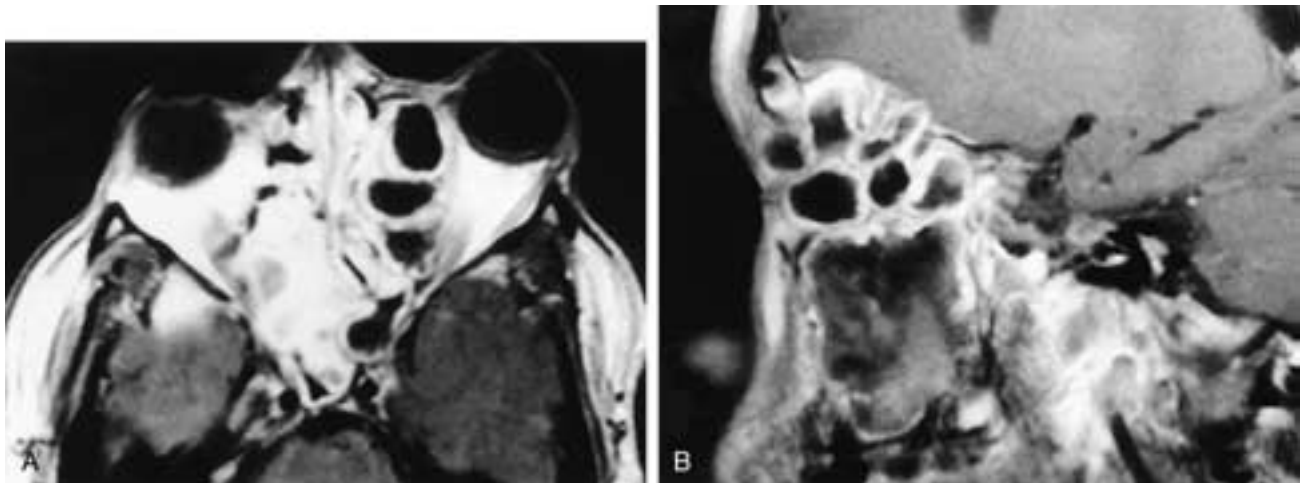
Axial (A) and sagittal (B) contrast-enhanced T1-weighted MR images show widening of the ethmoid complex by a mass that has also broken into the floor of the anterior cranial fossa and the left orbit. Enhancing mucosa is seen surrounding areas of signal void. The maxillary sinuses are also involved by the process. None of the sinuses were aerated on CT, and the areas of signal void were aspergillomas. This patient had aspergillosis.
